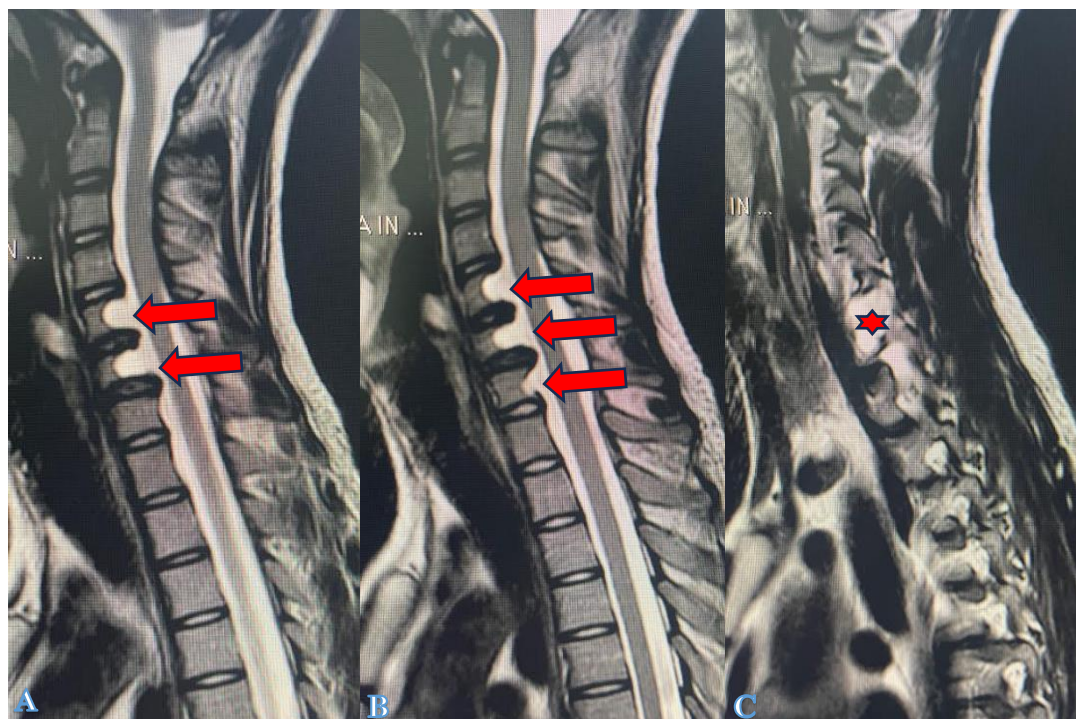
A-C): Sagittal MRI T2; posterior vertebral bone scalloping of C5, C6, C7 (arrows) and left meningocele at C6-C7 (*).
